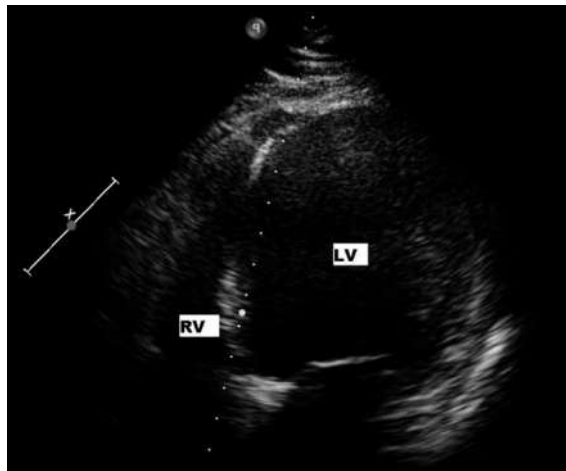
Echocardiography shows a dilated, hypokinetic left ventricle with round morphology.
